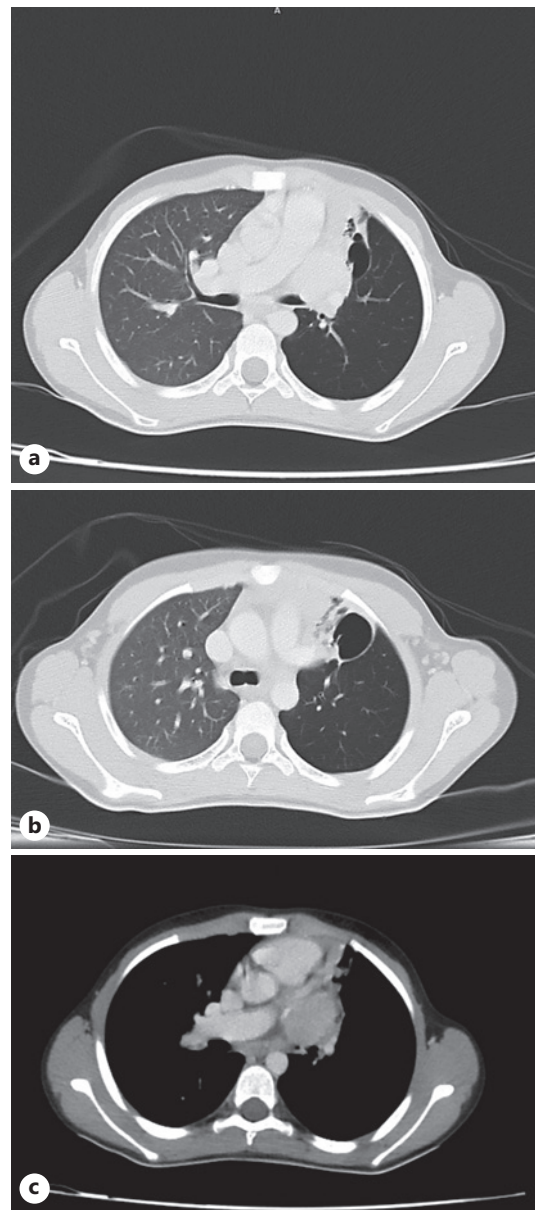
a Chest computed tomography (CT) showed a 32 × 25 mm mediastinal mass in the left middle upper mediastinal area with homogeneous intensity and a compressive effect on the left bronchus. A consolidation containing a cavity and air trapping in the left lung parenchyma due to the compressive effect of the mediastinal mass was also observed. b Chest computed tomography (CT) showed a consolidation containing a cavity, and air trapping in the left lung parenchyma due to the compressive effect of the mediastinal mass was also observed. c Mediastinal view of chest computed tomography (CT) showed a 32 × 25 mm mediastinal mass in the left middle upper mediastinal area with homogeneous intensity and a compressive effect on the left bronchus.
